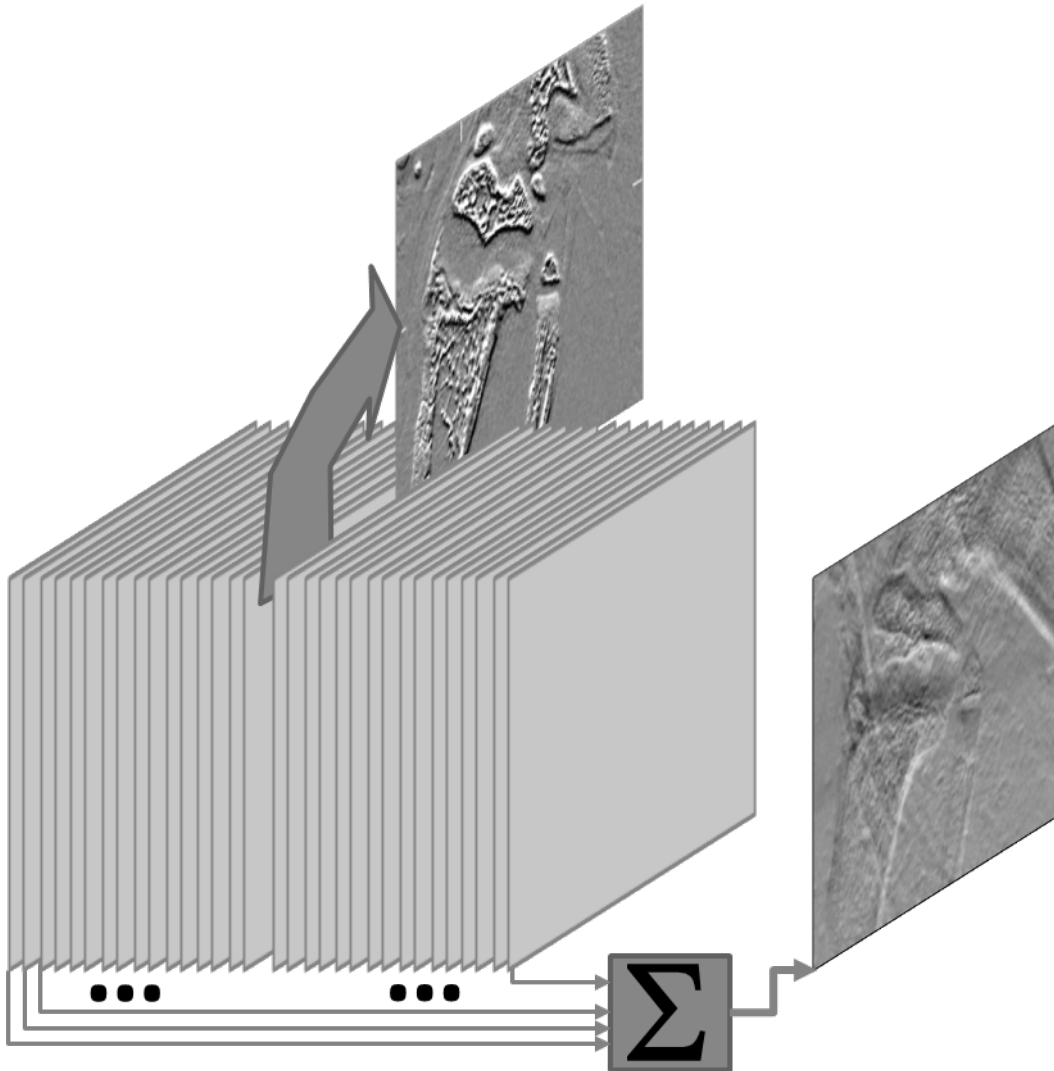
Relationship between reconstructed planes of a CT image and the corresponding projection image for an object. Example is for a DEI CT refraction image.
